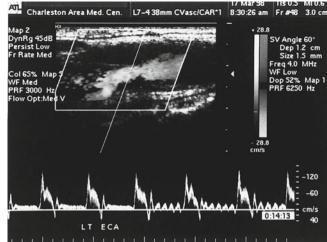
Color duplex ultrasound image of an external carotid artery. Note that the external carotid artery has a rapid upstroke and downstroke with a very low diastolic component. The diastolic notch is clearly seen, and tapping of the superficial temporal artery causes oscillations in the waveform (*bottom right*)
